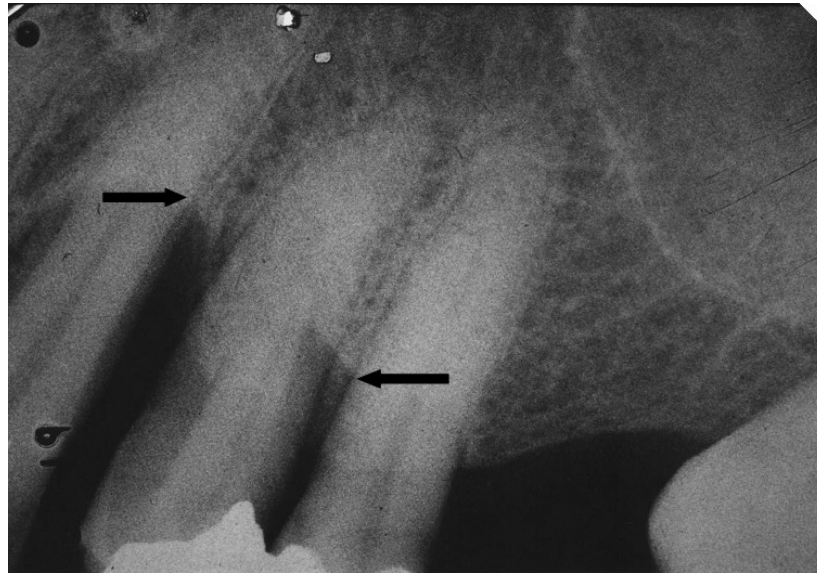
Radiograph showing bone loss around several teeth with an infrabony defect between two teeth (see arrow).
